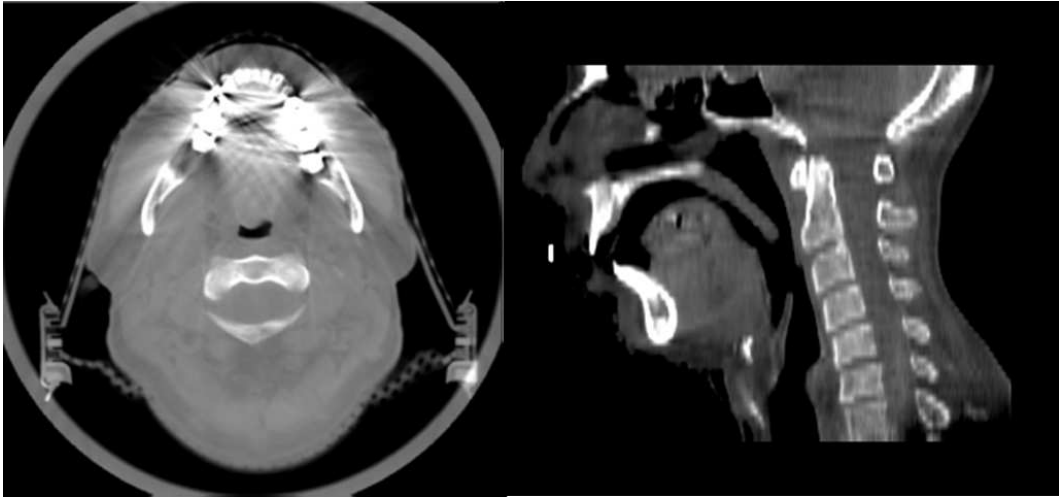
Initial CBCT volume (left) with fixes and ring effect versus pre-processed image (right). We can clearly note the contrast enhancement, as well as the removed tube and couch.
